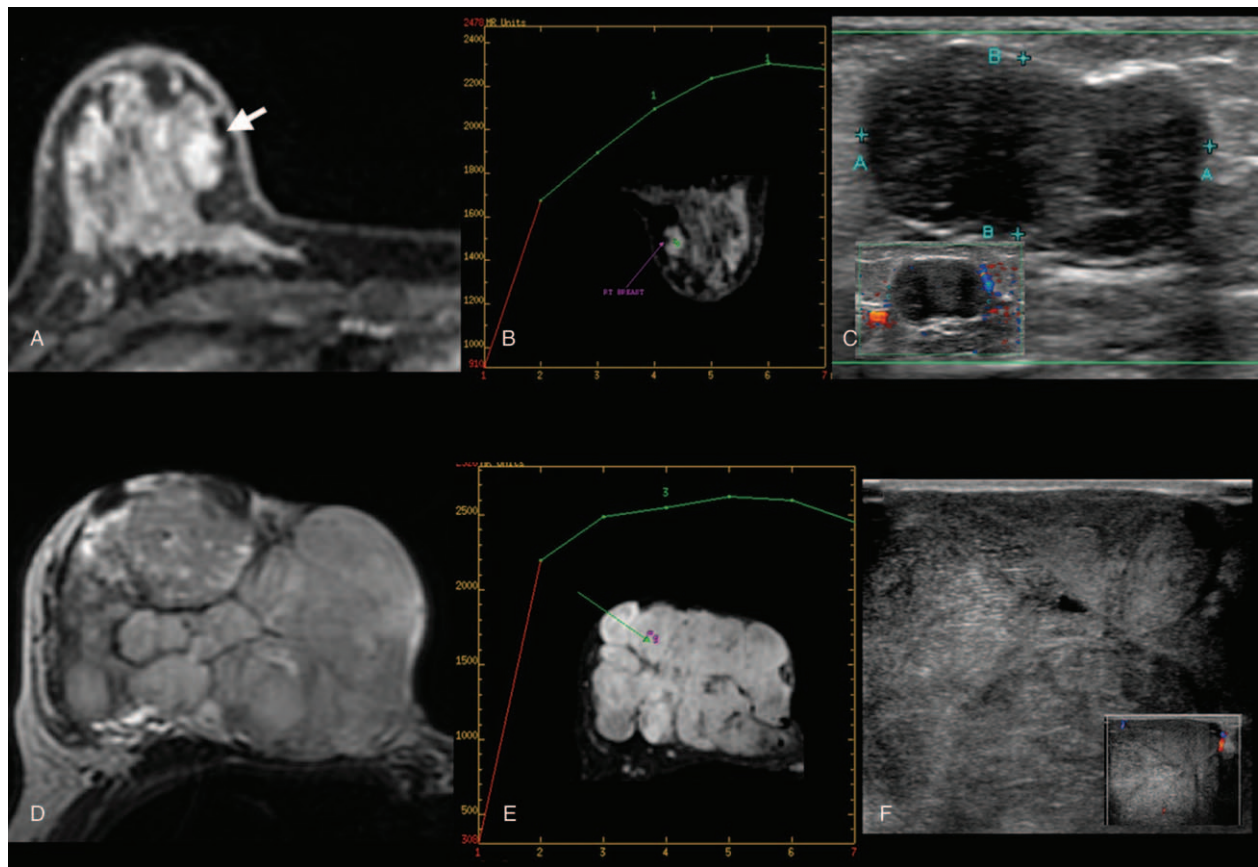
(A) Contrast-enhanced MRI image at 5-minute, shows persistent enhancement of a benign PT in the lower inner quadrant of the right breast with nonenhancing internal septae (B) The kinetic curve demonstrates continuous enhancement (Type 1) in keeping with benign lesion. (C) Corresponding ultrasound images showing a well-defined hypoechoic lesion with perilesional vascularity. (D) Axial T2W MR images of a borderline PT showing a large heterogeneously enhancing mass with internal septae, fat and cystic components occupying the entire right breast. (E) The kinetic curve demonstrates early enhancement that plateau at the later stages in keeping with type 2 curve. (F) Corresponding ultrasound images showing heterogeneous lesion with cystic component and no significant internal vascularity. PT=phyllodes tumor.
